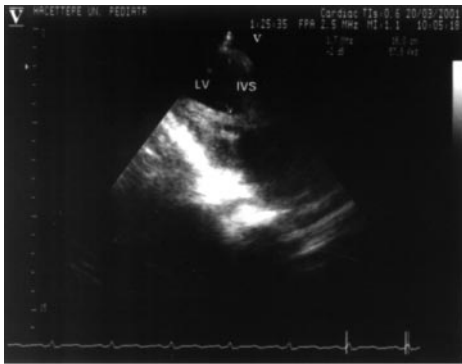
A subcostal short-axis section of an echocardiogram showing a hypertrophic muscle mass originating from the left ventricular (LV) free wall. IVS indicates interventricular septum.
